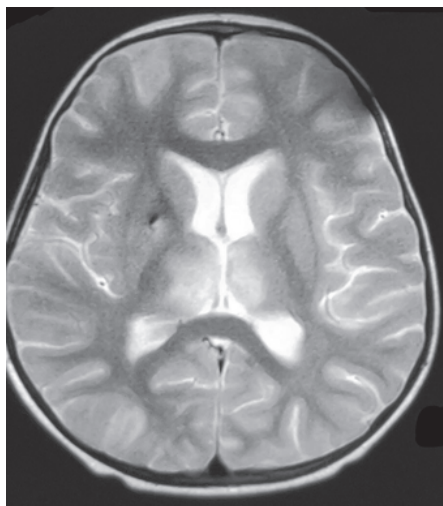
MRI brain axial T2 images - Typical thalamic involvement.
